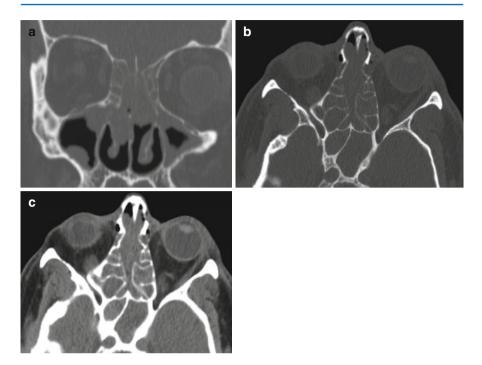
Coronal (a) and axial (b) bone window CT images demonstrating a polypoid mass originating from the left maxillary sinus, extending into the mid and posterior left nasal cavity, through an accessory ostium (*black arrow*), and prolapsing through the choana into the nasopharynx (*thick arrow*). Note the benign appearing expansion of the ostium compared to the other side (*white arrow*). In isolation, this is compatible with an antrochoanal polyp. (c) Soft tissue windows demonstrate the mass to be low density on CT, which correlates with a watery appearance on MRI (bright on T2) and pink appearance of polyposis on endoscopy. Conversely a lesion which may also be considered in this location, inverted papilloma, is often more solid appearing on endoscopy and soft tissue windows and often associated with more bone erosion on CT
